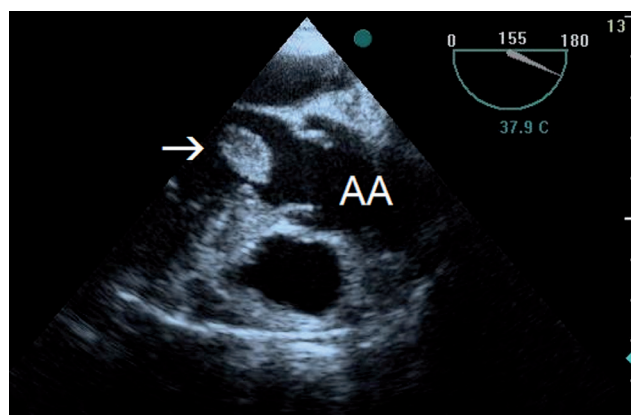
Transesophageal echocardiography. Papillary fibroelastoma (→) prolapsing during systole into the left ventricular outflow tract. AA – ascending aorta.
